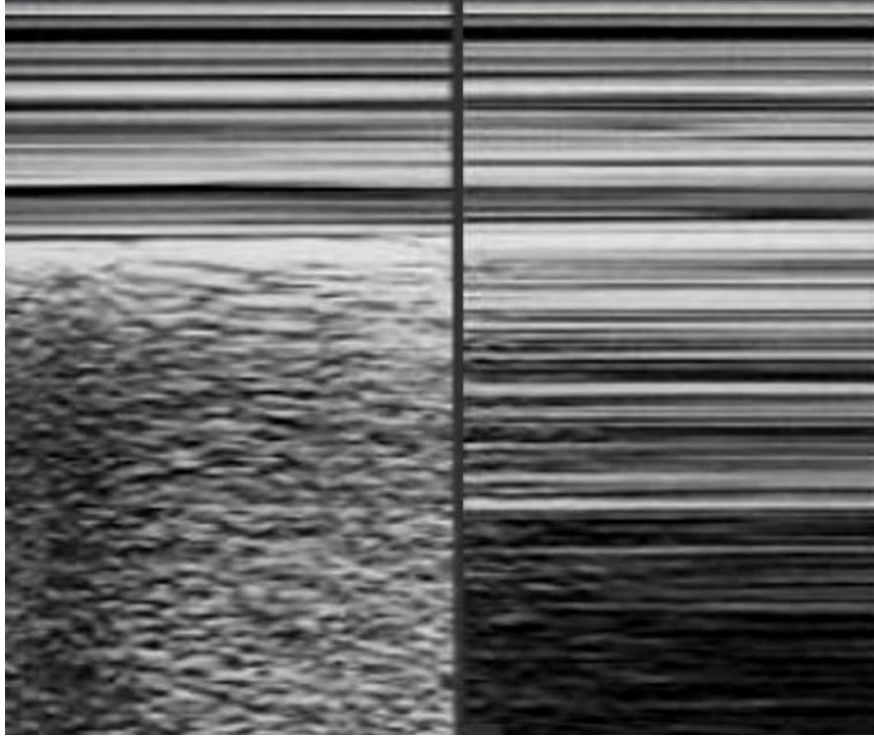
Ultrasound diagnosis of pneumothorax in M-mode. On the left side of the echogram, the ultrasound symptom of the seashore (indicating a normal pleura) is registered, on the right side is the bar code symptom, which is formed at point M during inspiration and indicates the absence of sliding of the visceral pleura in the pneumothorax area.
